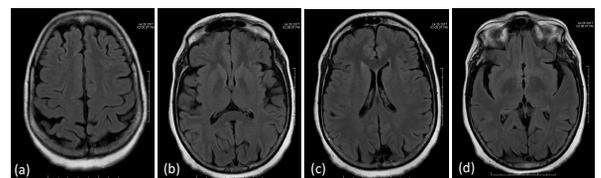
Axial fluid attenuated inversion recovery (FLAIR) images at different levels show diffuse atrophy of bilateral posterior parietal regions and occipital lobes.
